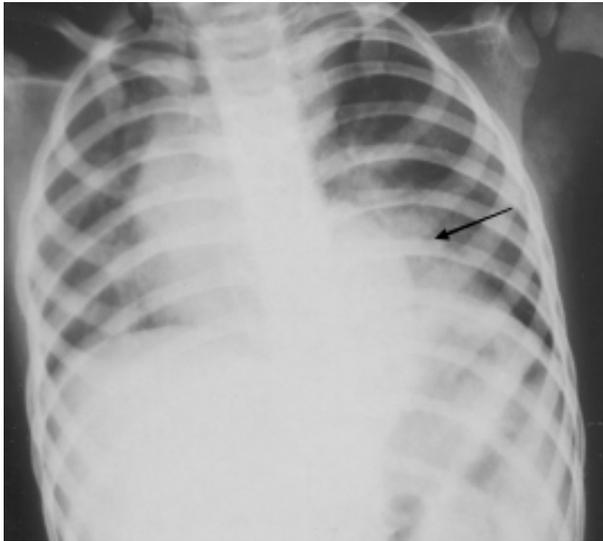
Chest radiograph showing left lower lobe consolidation (arrow).
